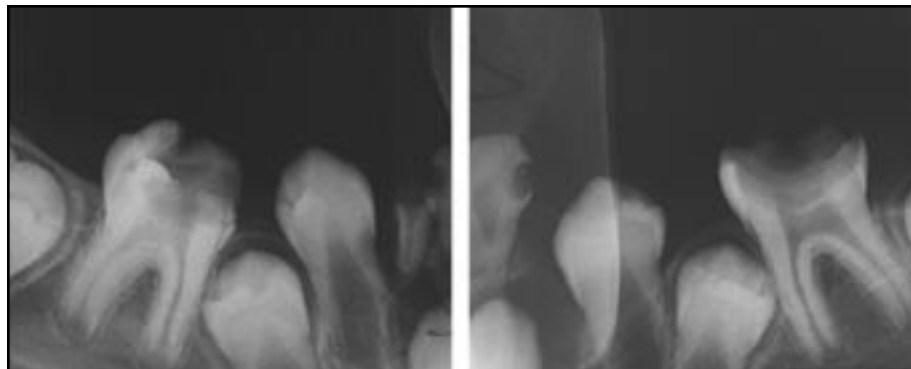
Preoperative periapical radiographs showing carious mandibular permanent first molars with open apices.
